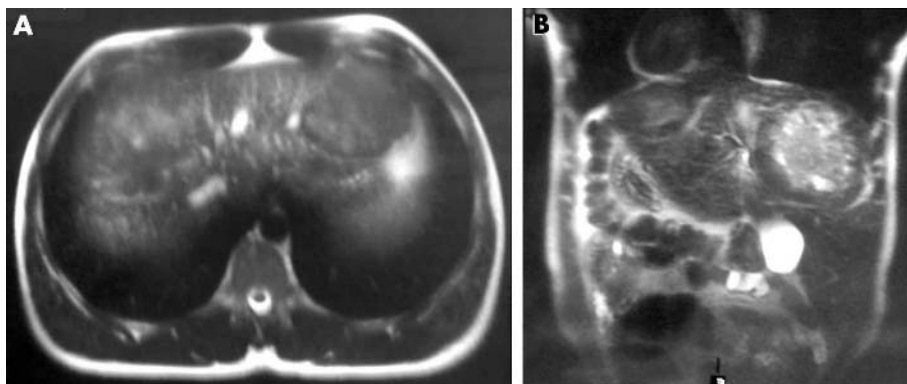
Magnetic resonance imaging showing heterogeneous signal in both liver tumours of the first patient.
